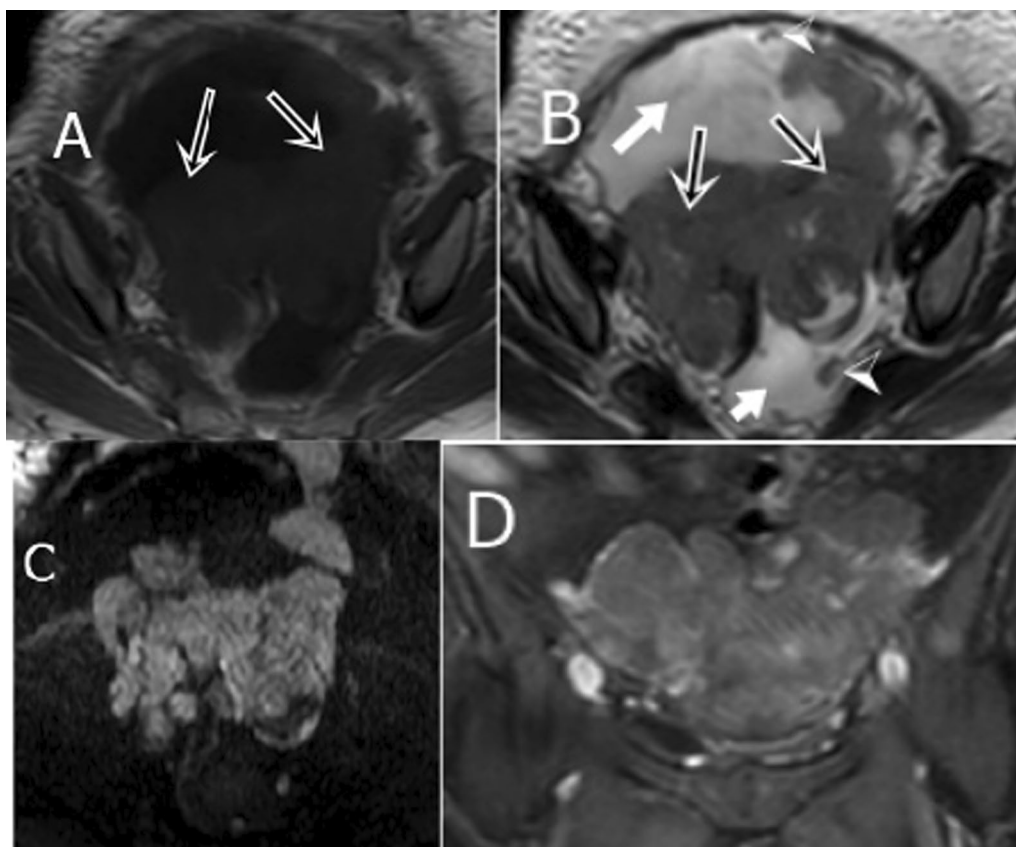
O-RADS MRI score 5 in a 56-year-old-female complaining form progressive abdominal enlargement, weight loss and malaise A Axial T1WI, B axial T2WI: Bilateral prominently solid adnexal lesions of low T1 and intermediate T2 SI (black arrows) with moderate ascites (white arrows) and few peritoneal nodules [arrow heads] C DWI: Restricted diffusion of the solid components D coronal postcontrast T1 WI showing heterogeneous contrast enhancement (with enhancement pattern categorized as high risk). This was pathologically proven bilateral high grade serous carcinoma involving both tubes and ovaries with detected lympho-vascular emboli
